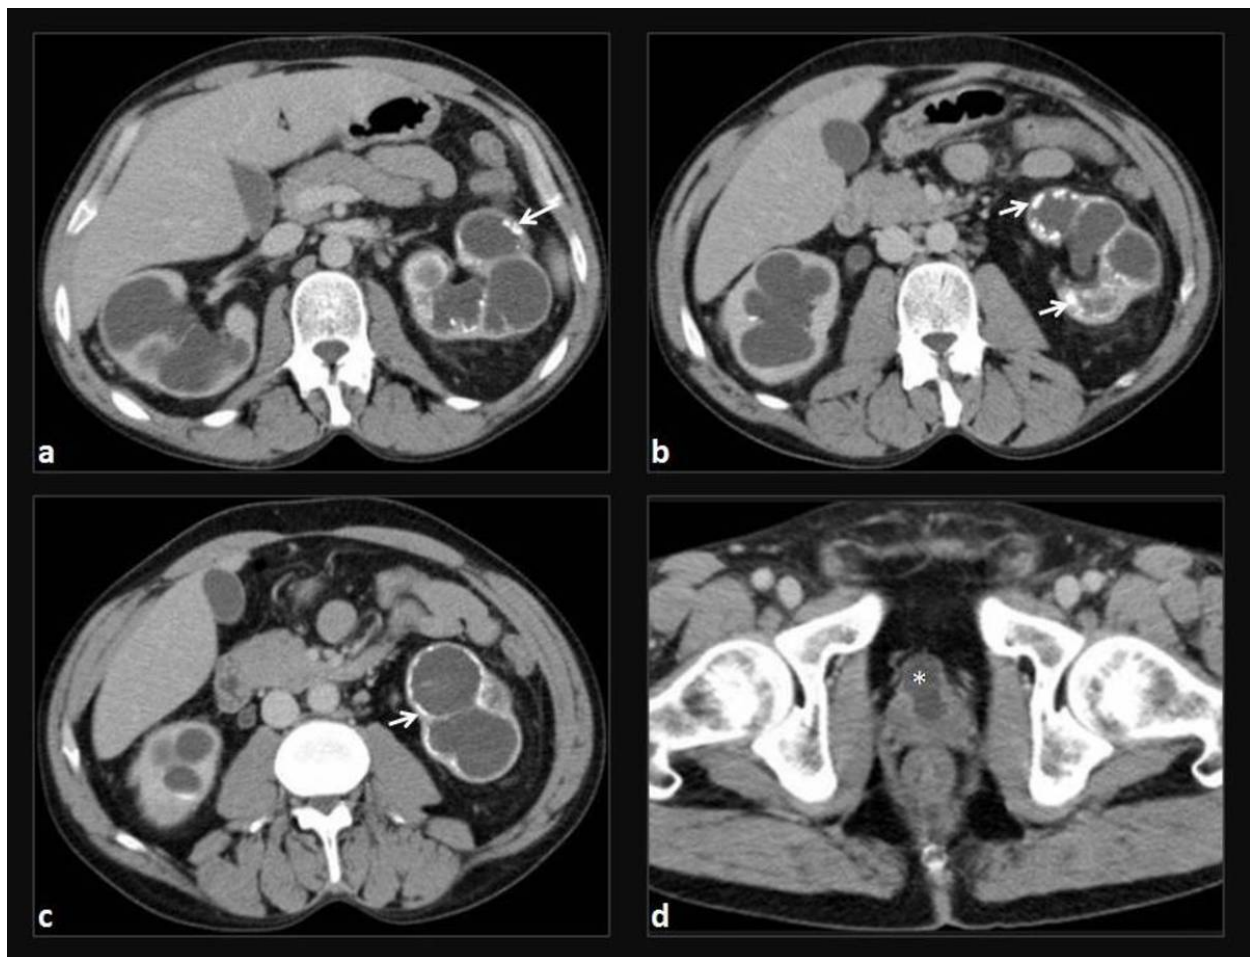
Renal tuberculosis. Axial contrast-enhanced CT images demonstrate bilateral dilatation of the collecting system, with marked reduction of the renal parenchyma
